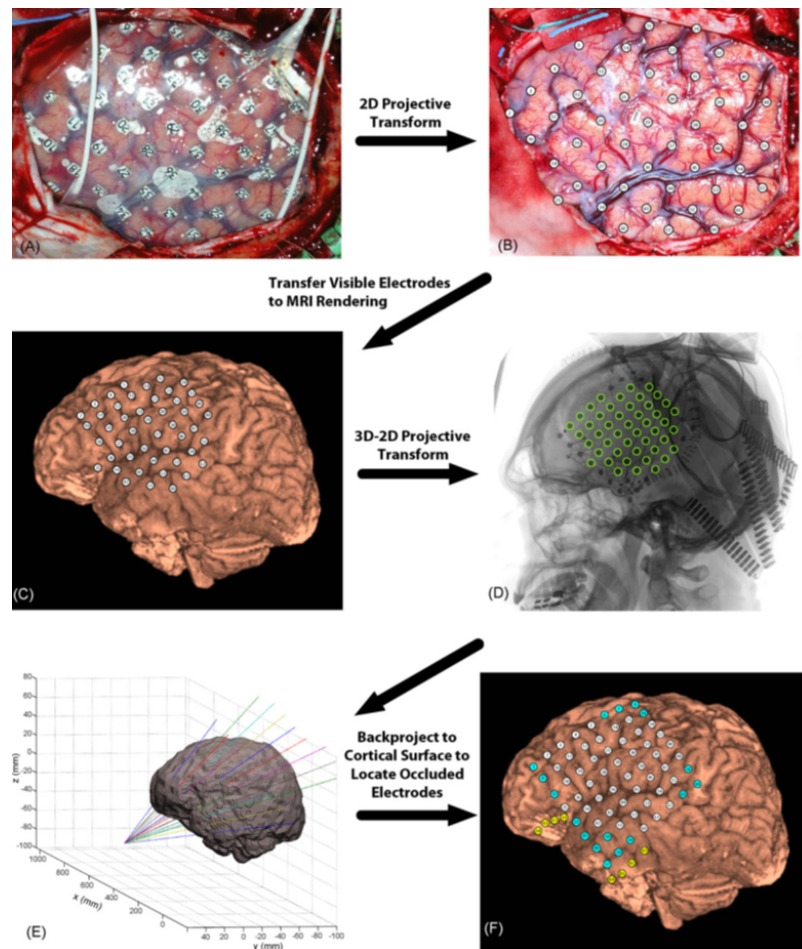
Procedure for registration of electrodes from photographs, MRI, and X-ray. Courtesy of [11].
